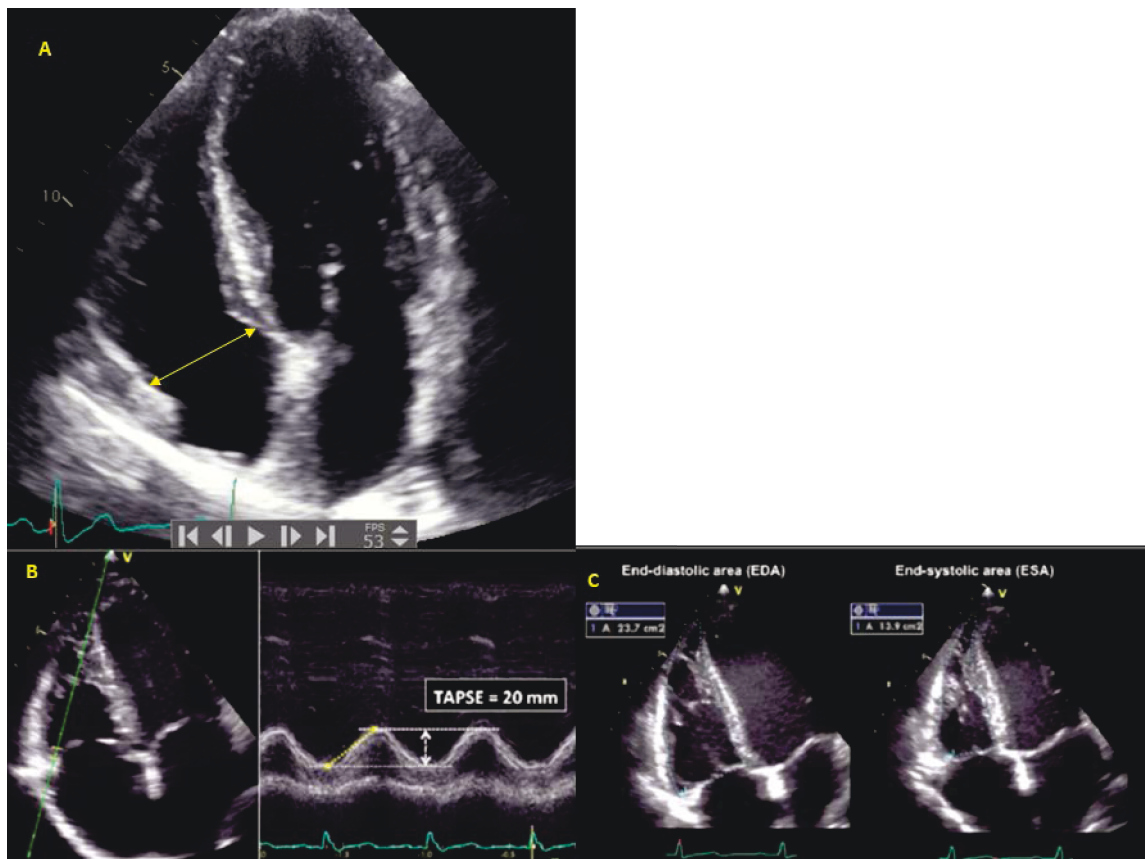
(A) Measurement of basal RV linear dimension; maximal transversal dimension in the basal 1/3 of RV inflow at end-diastole (RV-focused view); (B) TAPSE by m-mode, measured between end-diastole and peak systole. Proper alignment of m-mode cursor with the direction of RV longitudinal excursion should be achieved from the apical approach; (C) Example of measurement of RV areas: manual tracing of RV endocardial border from the lateral tricuspid annulus along the free wall to the apex and back to medial tricuspid annulus, along the interventricular septum at end-diastole and at end-systole. Trabeculations, papillary muscles and moderator band are included in the cavity area. [Journal of the American Society of Echocardiography 2015 281-39.e14DOI: (10.1016/j.echo.2014.10.003) Copyright © 2015 American Society of Echocardiography]
